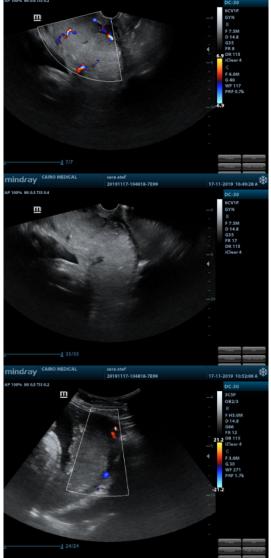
Ultrasound imaging of case 6
